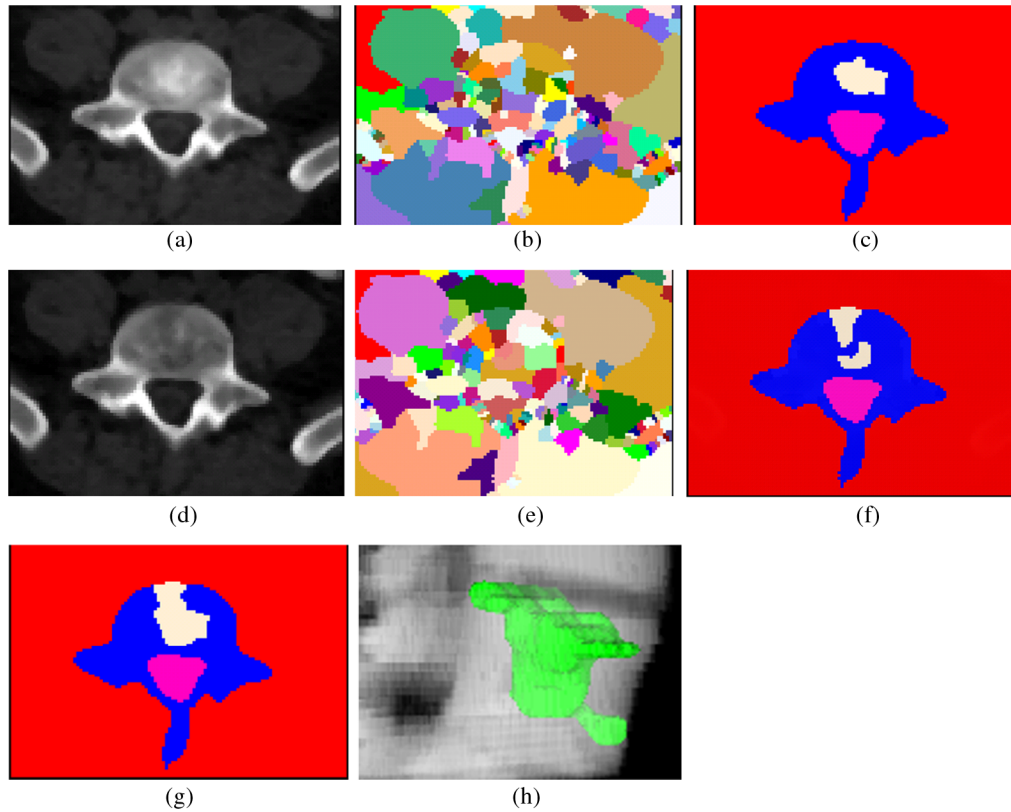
Lesion candidate detection and segmentation. (a) Sclerotic PET/CT synthesis of Fig. 1(c); (b) watershed result of (a); (c) graph cut result of (b); (d) lytic PET/CT synthesis of Fig. 1(c); (e) watershed result of (d); (f) graph cut result of (e); (g) merging of sclerotic and lytic detections; and (h) 3-D mixed metastasis detection.
